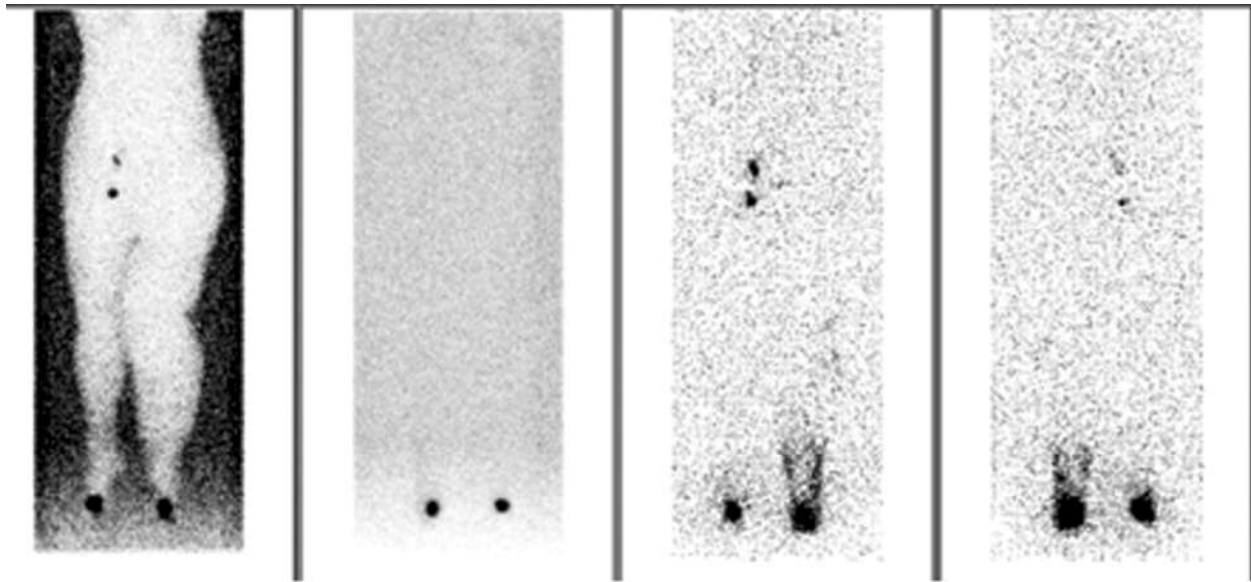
Lymphoscintigraphy image.
